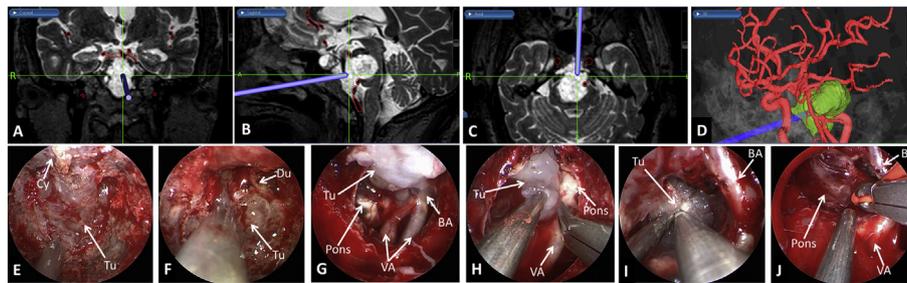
A–D: Use of stereotactic navigation guidance system with MR images. Excellent accuracy achieved to localize the precise site of the intrapontine lesion. E–J: Endoscopic endonasal view of surgical field. Cy, cyst; Tu, tumor; Du, dura; BA, basilar artery; VA, vertebral artery.
